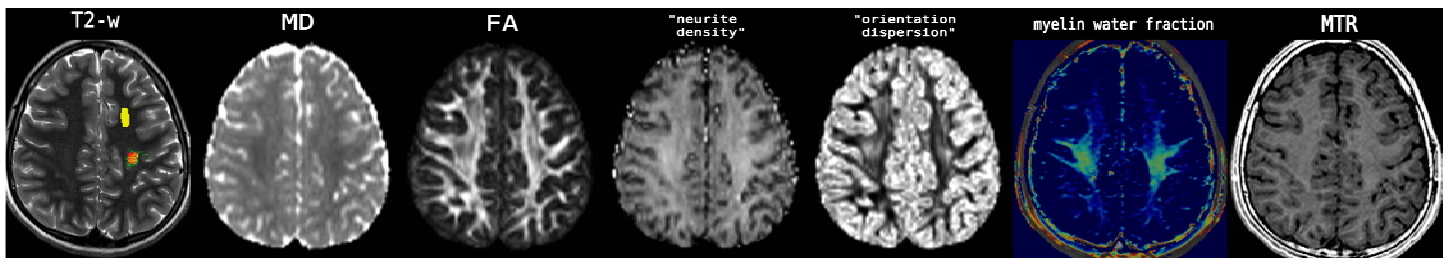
T2-weighted image (left) of a 14y-old healthy subject with ROI-definition in yellow (frontal) and red (CST), guided by the CST-fibres (green).
